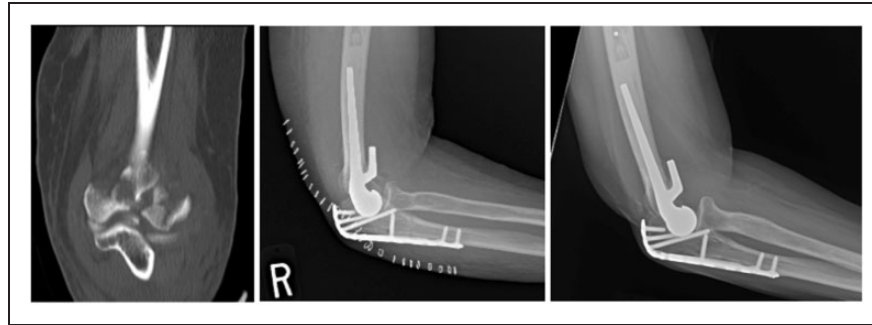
A, Preoperative coronal CT image demonstrating a comminuted distal humerus fracture. B, Two-week postoperative lateral radiograph of EHA and olecranon osteotomy. C, Three year follow up lateral radiograph.
